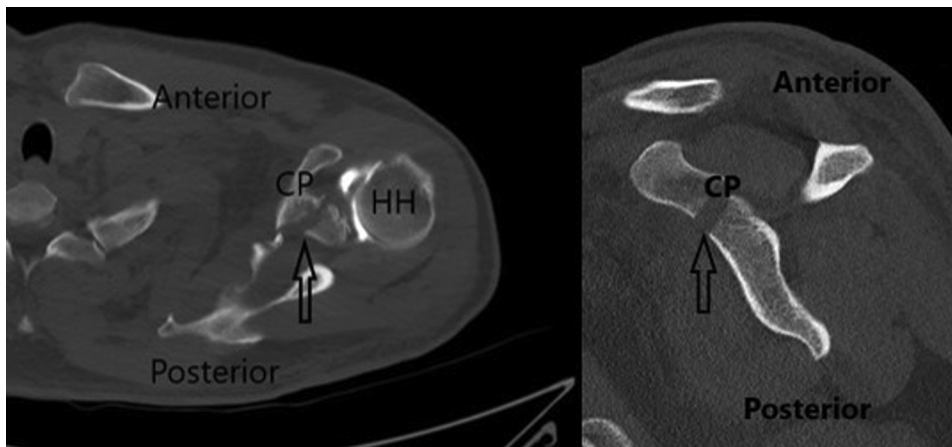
Computed tomography scan of a left shoulder (axial and sagittal views) showing a coracoid process (CP) base fracture with displacement of 8 mm (arrows). The examination is performed with the patient supine and the arm in neutral rotation. (HH, humeral head.)
